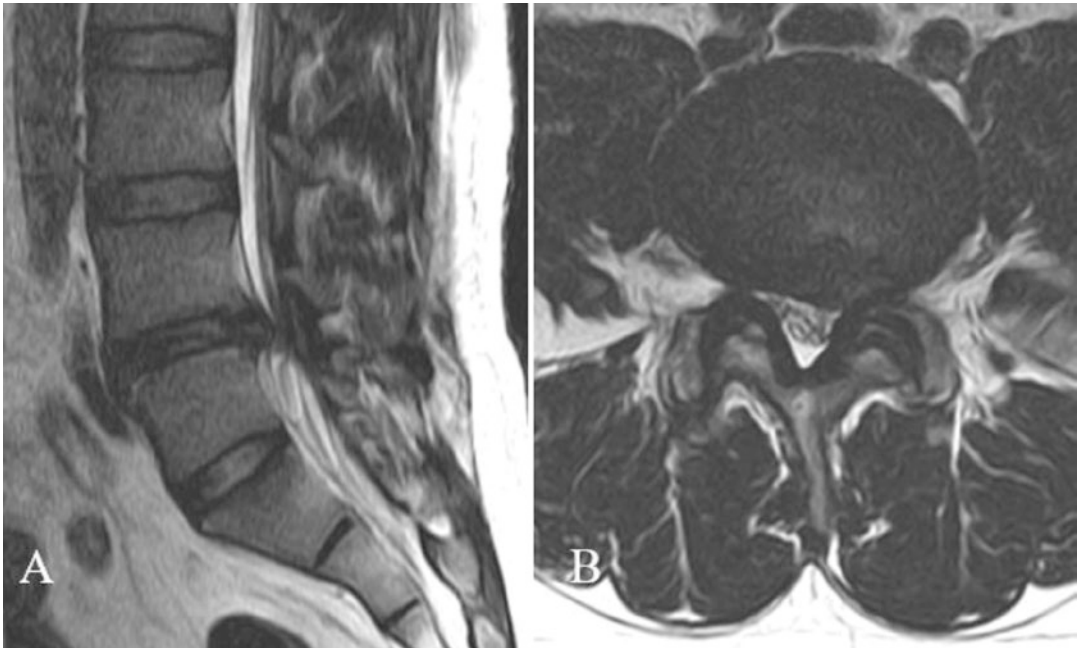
(a) Preoperative MRI shows HLD L4/5 (sagittal view). (b) Axial view shows left side paracentral HLD at L4/5 intervertebral disc level
